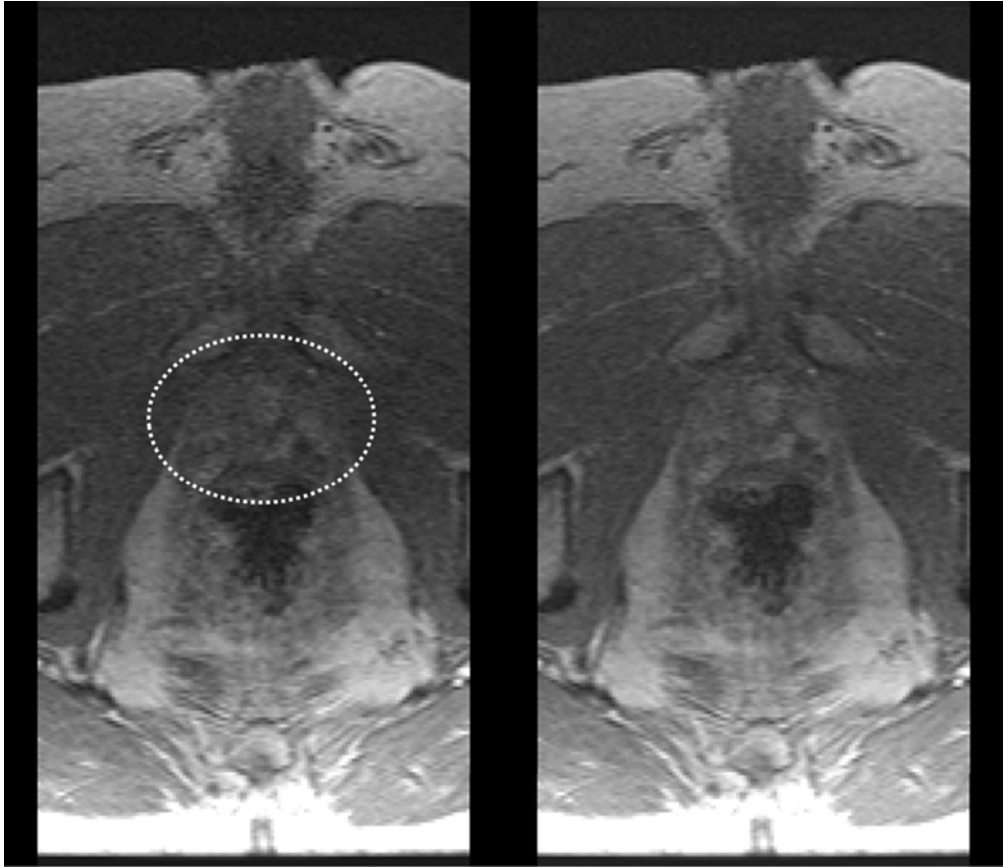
Comparison of 12-coil (left) and 32-coil (right) reconstructions of prostate DCE-MRI in a patient with BMI 26.6. Prostate is identified within the white ellipse. Radiologists #1 and #2 both assigned scores of (+2, 0, 0, +2) for (perceived SNR, artifact level, sharpness, overall preference) where positive scores reflect preference for the 32-coil result.
